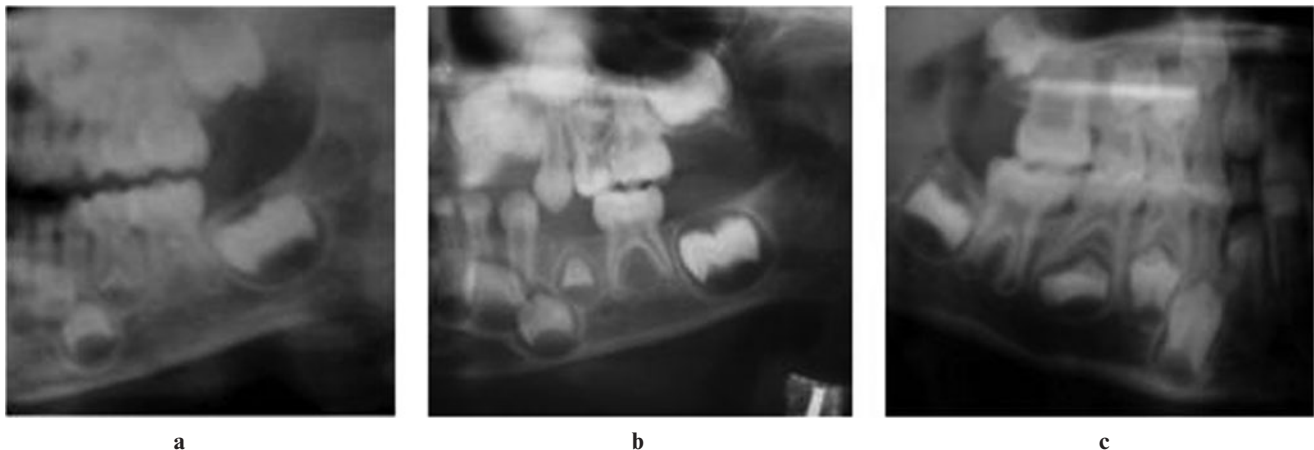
Radiographs showing upper and lower jaws with developing dentition of children aged (a) 2 years 6 months, (b) 3 years 9 months and (c) 6 years 8 months
